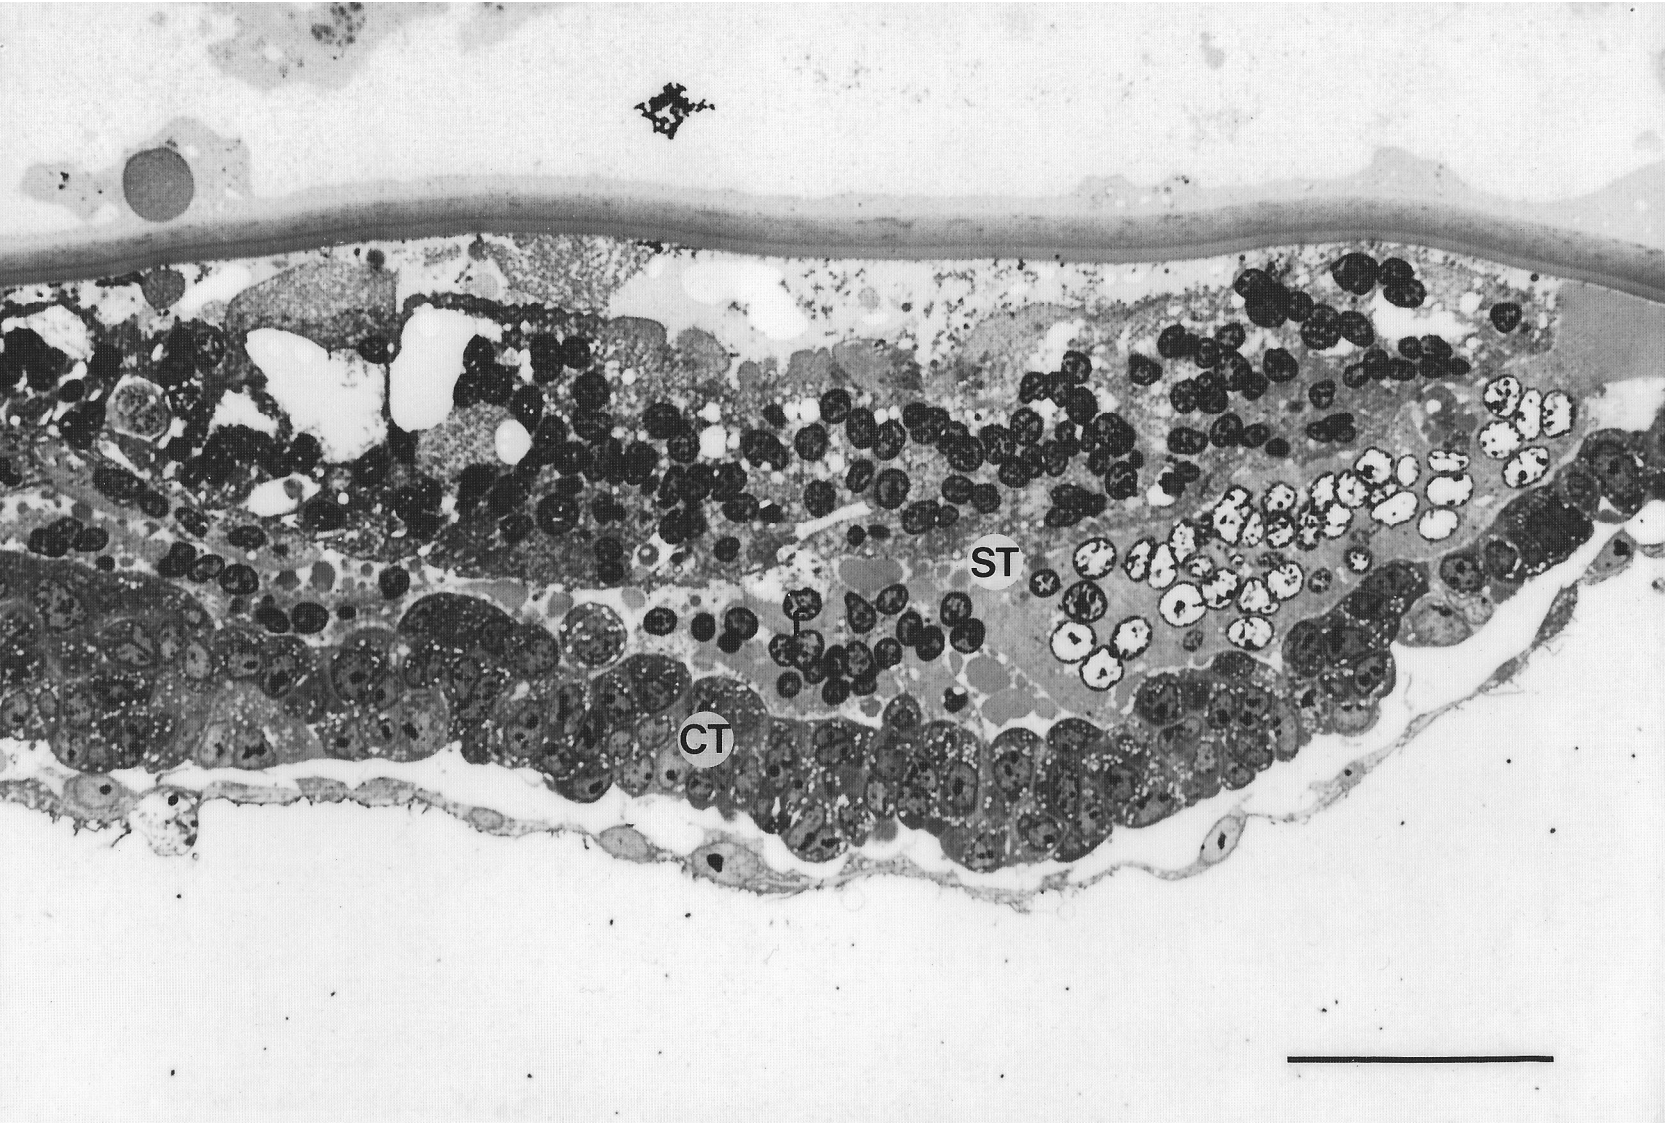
DETAIL OF THE TROPHOBLAST NEXT TO THE EMBRYONIC ANLAGE OF THE SITE SHOWN IN FIG. 1. THIS PART OF THE TROPHOBLAST IS NORMALLY HIGHLY INVASIVE AND INVOLVED IN THE FORMATION OF THE CHORIOALLANTOIC PLACENTA. IN THIS CASE IT HAS NOT BEEN ABLE TO ESTABLISH CONTACT WITH THE ENDOMETRIUM SINCE THE NON-DISSOLVED BLASTOCYST COVERINGS (ABOVE) REMAIN INTERPOSED. NOTICE THE THREE LAYERS OF THE BLASTOCYST COVERINGS (GLOIOLEMA, MUCOPROTEIN LAYER, NEOZONA). THE SYNCYTIOTROPHOBLAST (ST) SHOWS SIGNS OF DEGENERATION, APPARENTLY PROGRESSING IN SEVERAL WAVES. THE CYTOTROPHOBLAST (CT) APPEARS HEALTHY. BAR = 50 μ m. (COMPARE WITH FIG. 8).
